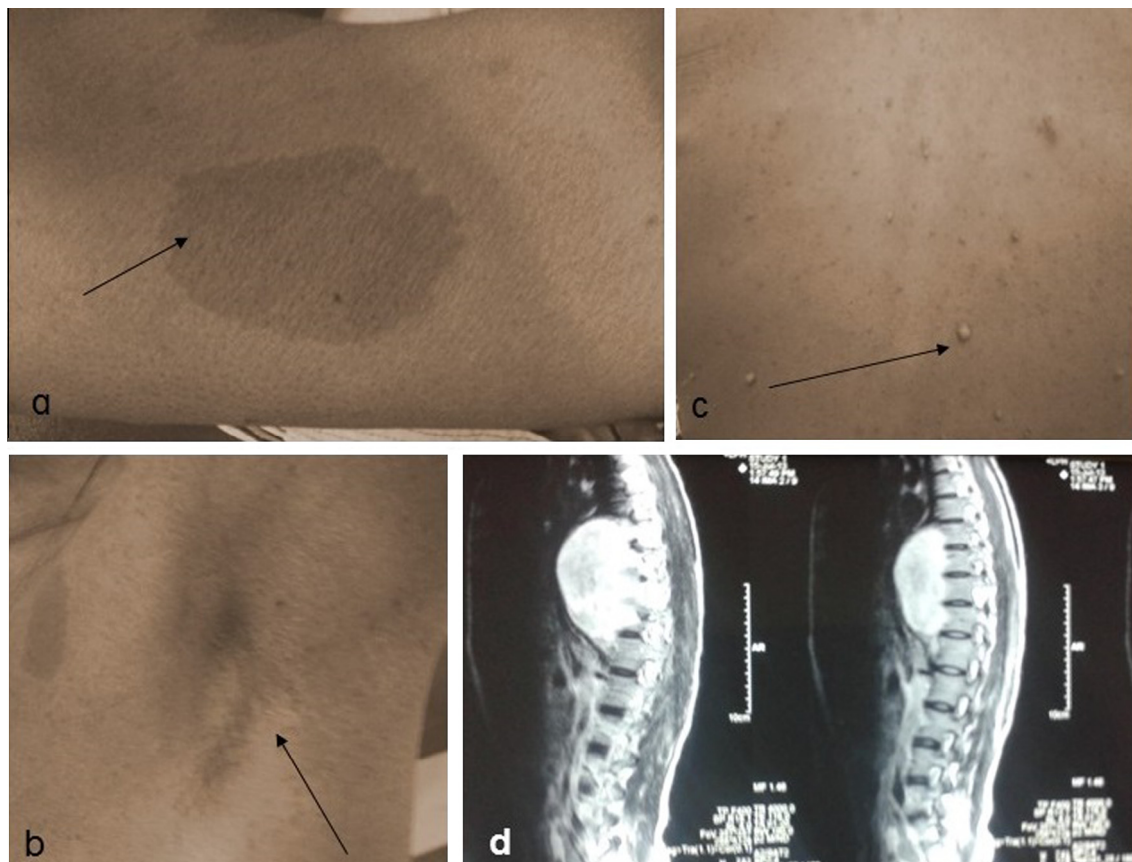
Showing (a) cafe au lait spots, (b) axillary freckling, (c) neurofibromas, and (d) MRI spine showing plexiform neurofibroma at the level of D10.
